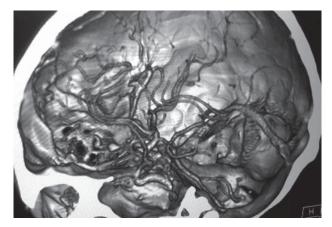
CT angiography of cerebral vessels showing two sacular aneurysms in the forntobasal branch of left anterior cerebral artery
